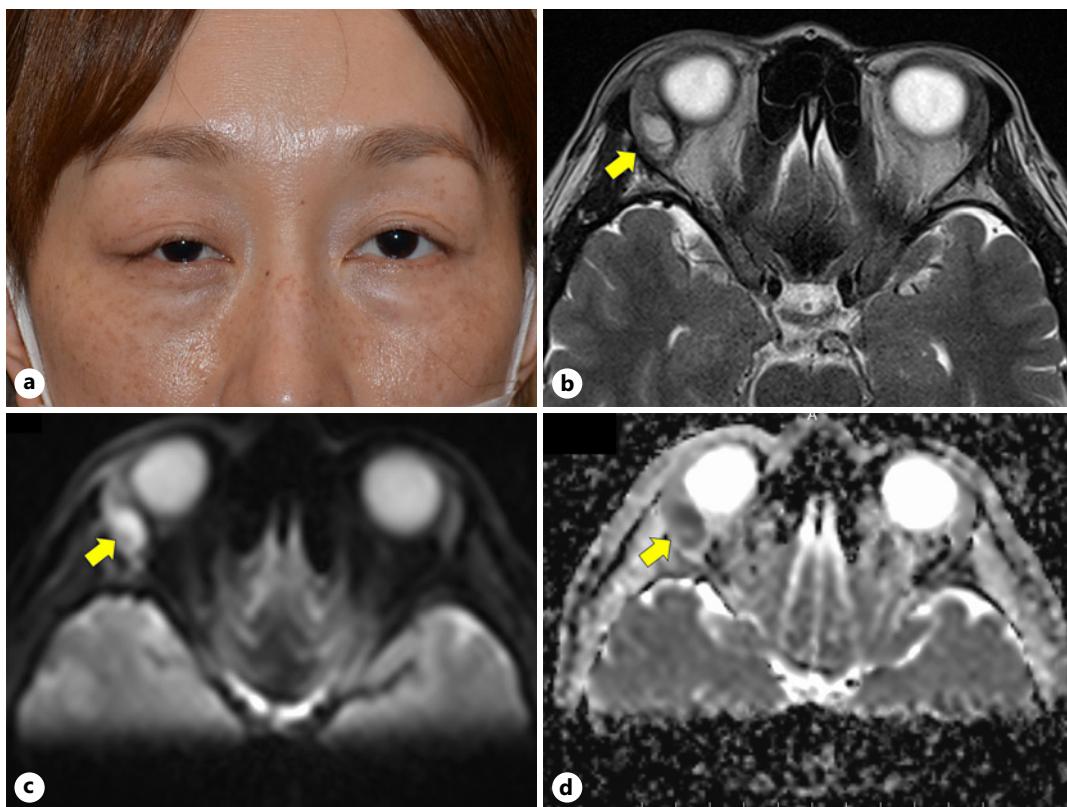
Images of the case. a Patient face photo taken on the first examination showing eyelid swelling on the right side. b–d Magnetic resonance images (MRIs). b, c Axial T2-weighted MRI (b) and diffusion-weighted image (c) showing high signal intensity lesions in the right lacrimal gland (arrows). d ADC map showing a lacrimal gland lesion with a low signal intensity (arrow).
